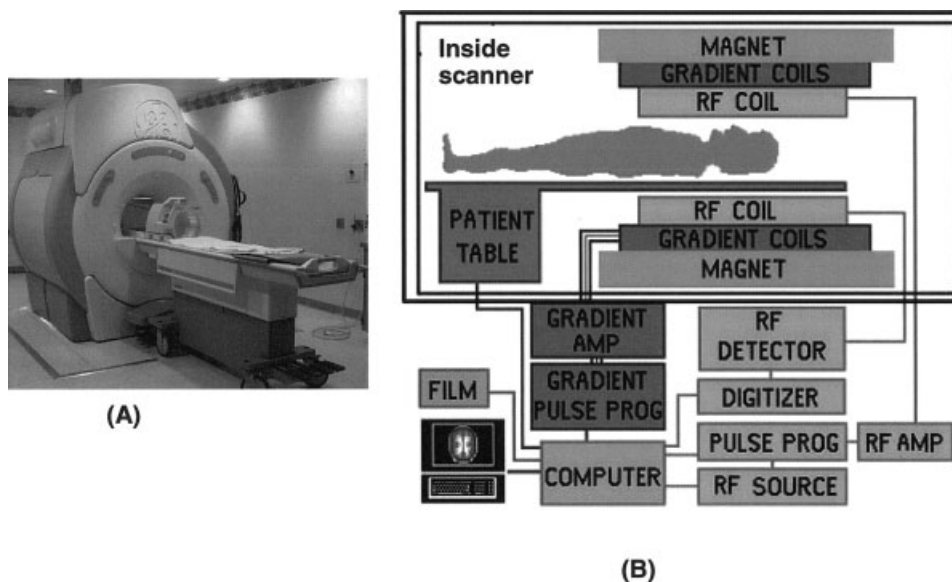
(A) Scanner. (B) The components of a scanner used for MRS and MRI studies.
